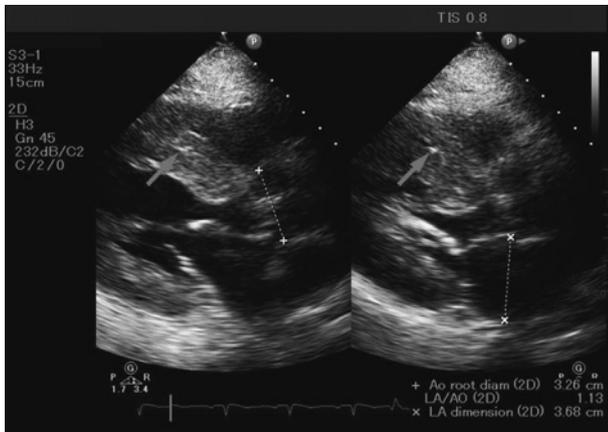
Transthoracic echocardiography showing thickening and calcification of aortic cusps and “granular sparkling (arrowheads)” in the intraventricular muscle.
